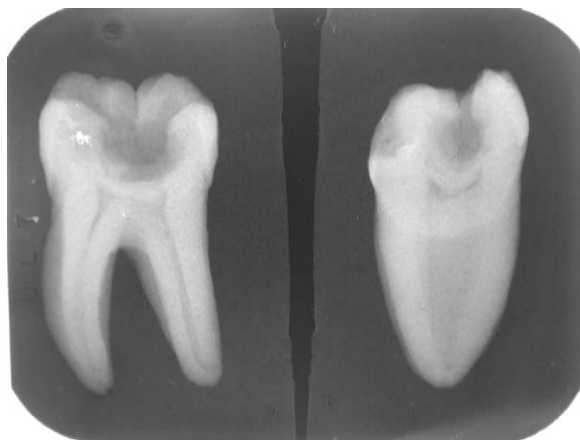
The mesiodistally directed radiograph indicates a flattened distal root canal in a mandibular first molar. In the same tooth, the faciolingual direction of the routine radiograph gives an impression of a round-shaped distal canal.
